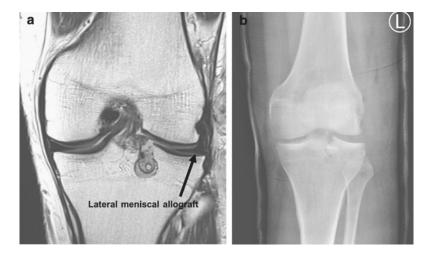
a Immediate postoperative coronal magnetic resonance image of the left knee shows no extrusion of the graft. b The left knee is immobilized in full extension and slightly varus with a long leg cast after lateral meniscal allograft transplantation
